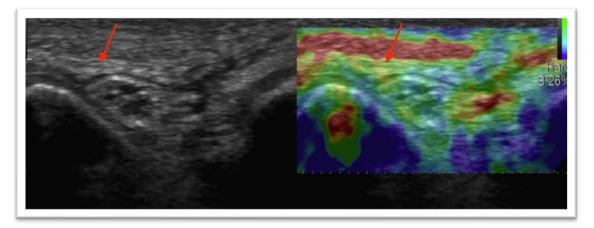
Patient with the forearm supinated and the elbow extended at approximately 3 months post-treatment. The B-mode and elastosonography images show thickening and expansion of the scar tissue (red arrow). The thickness of the Osborne ligament and scar tissue is 0.67 mm, measured above the ulnar nerve.
